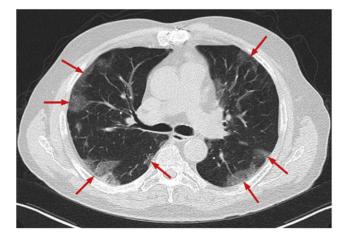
Axial chest CT image shows bilateral, multifocal ground-glass opacities that were predominantly located peripherally
